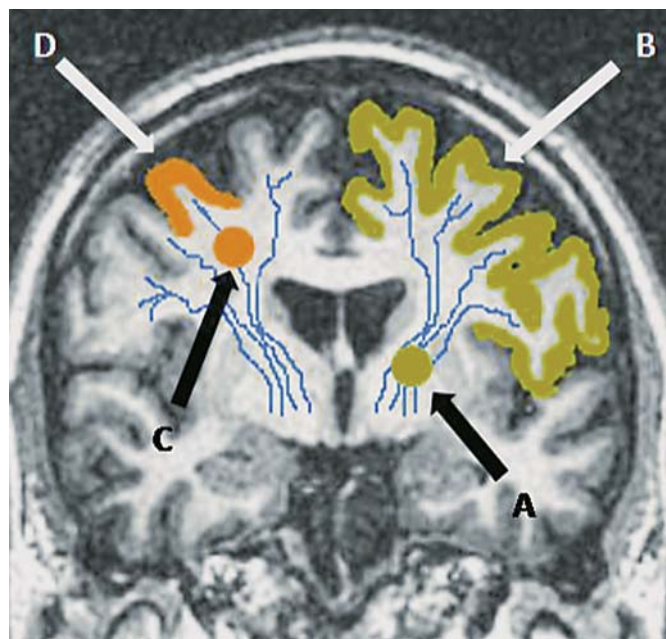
Coronal T₁-weighted MRI brain to demonstrate how the site of a small subcortical (lacunar) infarct could influence clinical presentation. A small subcortical infarct lying in the left internal capsule, i.e. deep white matter (A), would cause functional disconnection of a large area of cortex (B, shaded). A peripheral small subcortical infarct lying close to cortex (C) would affect only a limited area of cortex (D, shaded), and could mimic a mild cortical stroke.
